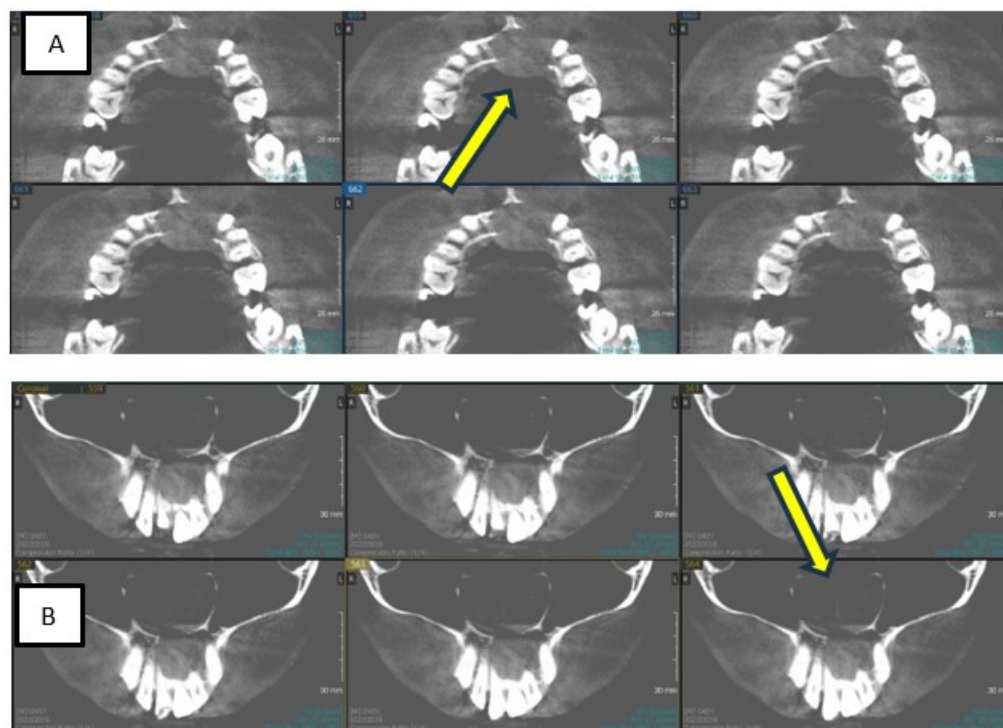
CBCT radiograph, (A)axial and (B) coronal view of the lesion
